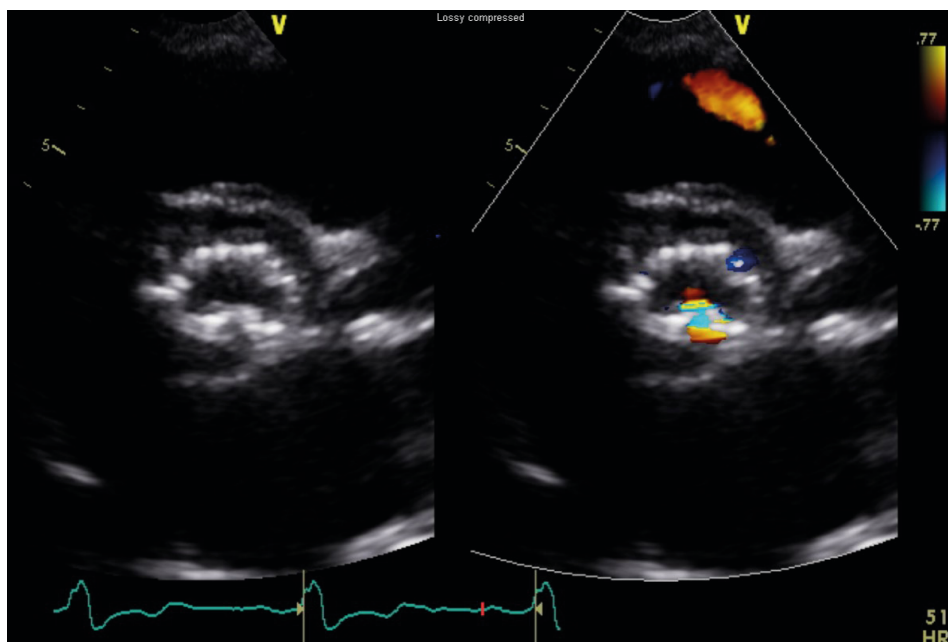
Serial echocardiography after 1 day post-TAVR revealed valve distortion (Left) with mild paravalvular leakage (Right).
